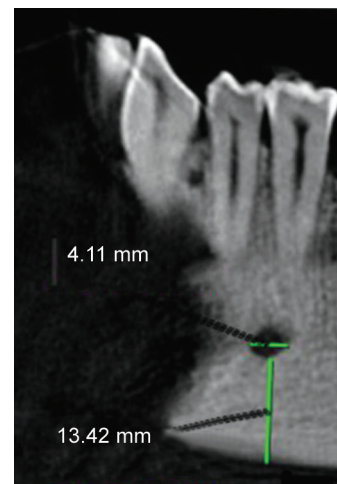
CBCT scan image showing internal length of MF and distance between the lower border of MF and lower border of the mandible
